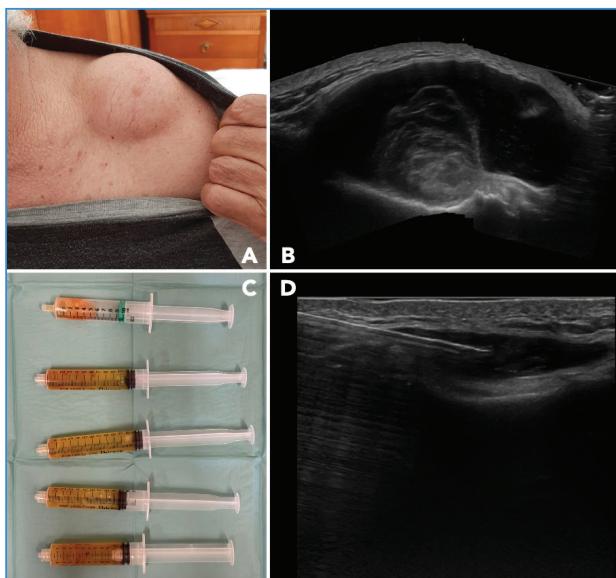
Image of Recurrent Acromioclavicular Joint Cyst: physical examination, ultrasound-diagnosis and ultrasound-guided management
